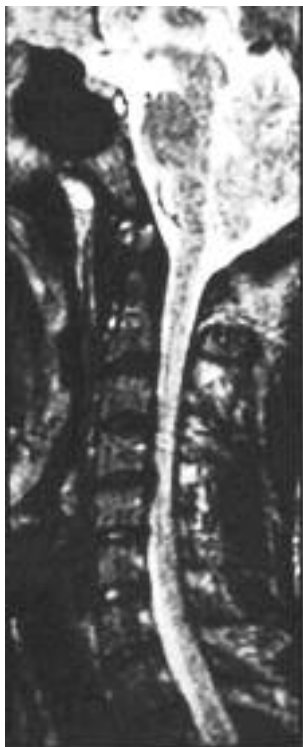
Preoperative (1995), T2-weighted, sagittal magnetic resonance image showing both a large disc herniation at C4/C5 causing spinal cord compression and signs of degenerative disc disease at C3/C4 and, to a lesser extent, at C5/C6.
